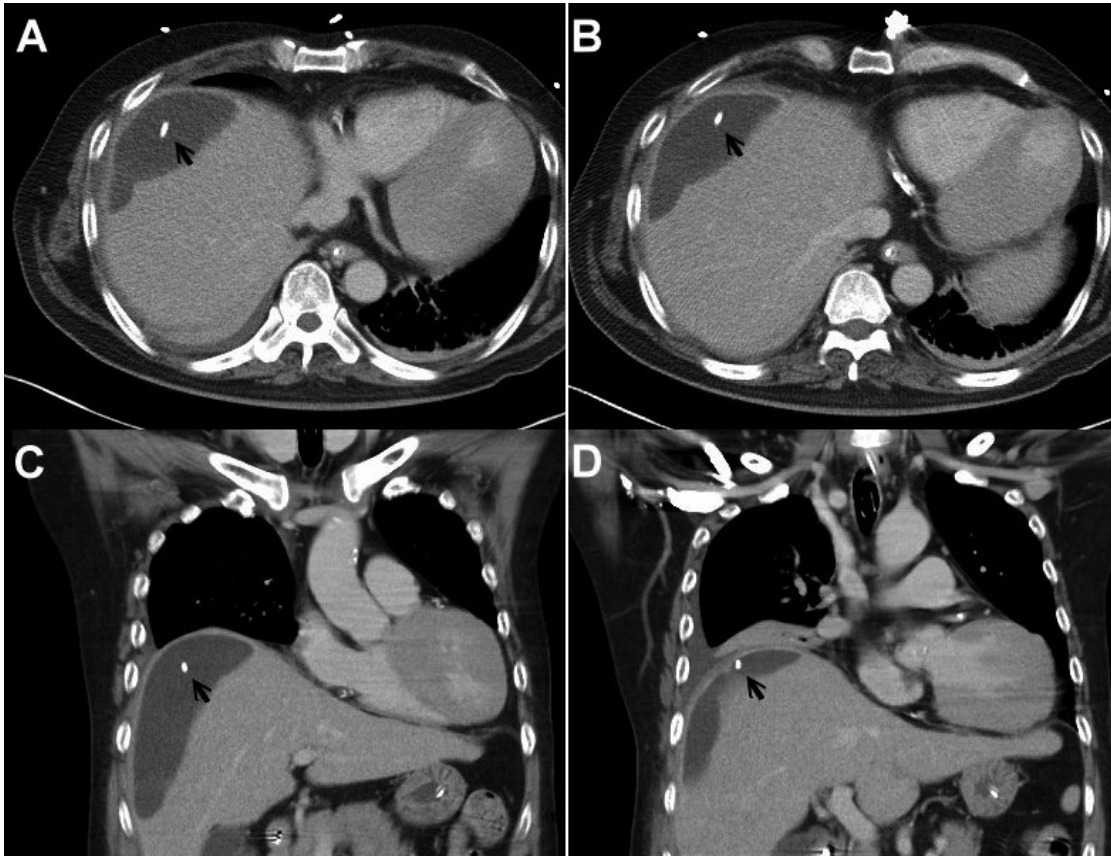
Chest CT scan. (A, B) The transverse sections of the thorax. (C, D) The frontal sections of the thorax. The arrowheads denote the distal tip of the VP shunt. Note that the distal tip of the VP shunt was located between the liver dome and the right-side hemidiaphragm. A cystern of fluid accumulation in the right subphrenic area was also found.
